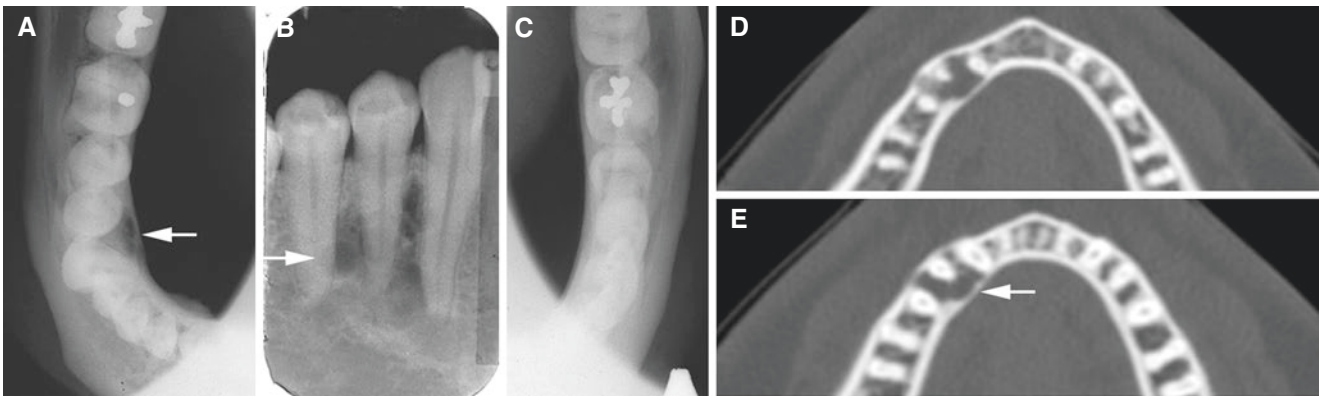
Ameloblastoma, solid/multicystic, mandible, with follow-up; 31-year-old male with some swelling (pain-free) in the right anterior mandible. (A) Occlusal (axial) and (B) intraoral (periapical) views show multilocular, slightly expanding radiolucency (*arrow*).
